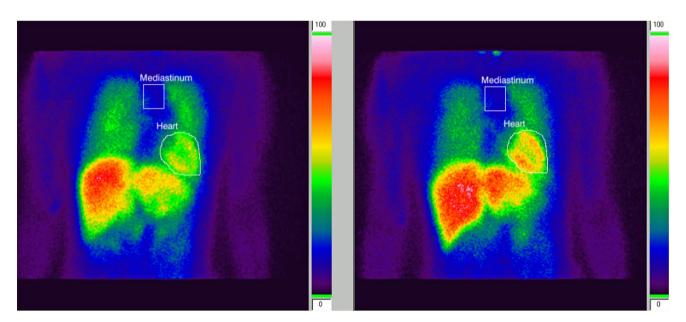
Myocardial scintigraphy (left: 0 min; right: 148.2 min) revealed no reduction in accumulation. The heart-to-mediastinum ratio was 2.60 (0 min) to 3.12 (148.2 min), and the heart washout rate was 5.5%.
